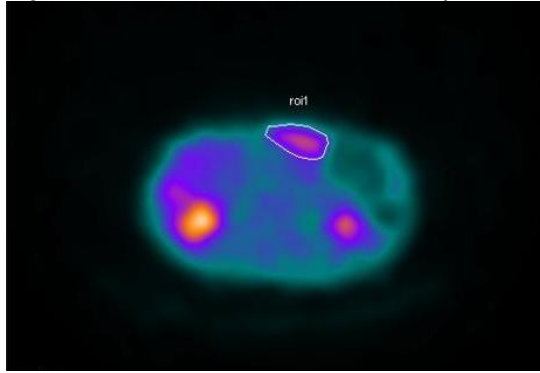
Regions of interest (ROI) of gastric lesion on SPECT of patient (male, 54yrs, lower gastric cancer, SUVmax 5.51)
